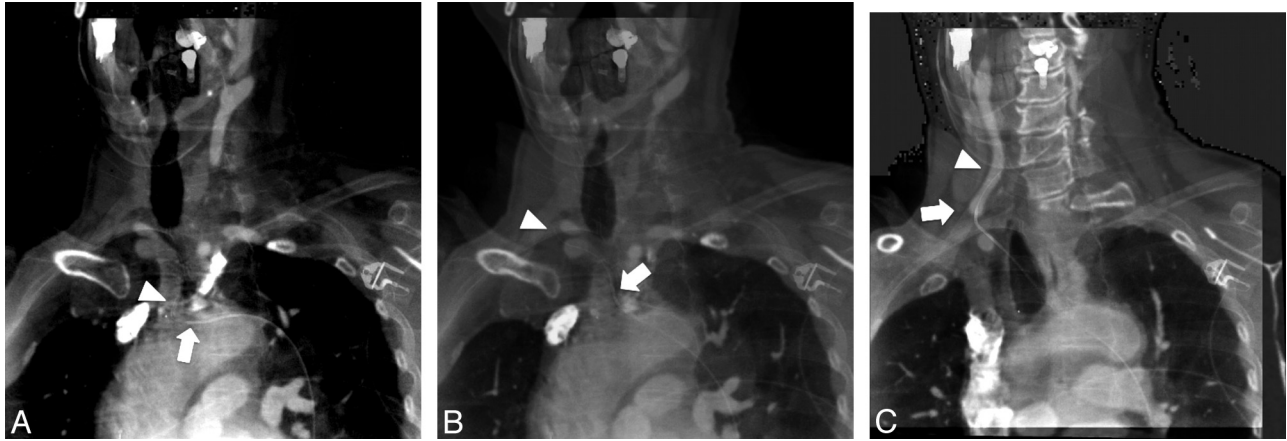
A 68-year-old woman was referred for diagnostic angiography of an aneurysm in the cavernous portion of the internal carotid artery. *A*, AP view of real-time fluoroscopy with superimposition of an MIP of a previously acquired CTA. A 5F Bern catheter (Boston Scientific, Natick, Massachusetts) with a Terumo wire (Terumo Medical, Somerset, New Jersey) can be seen in the brachiocephalic trunk. *B*, The wire is shown in the proximal right common carotid artery. The superimposed MIP of the CTA does not correlate well with fluoroscopy due to the different depth of the aortic arch and the proximal common carotid artery in the AP projection. *C*, After manual adjustment of the depth of the MIP, the road-mapping of distal vasculature until bifurcation is available again for further navigation of the catheter. Arrows indicate the tip of the catheter, and the arrowheads indicate the tip of the wire.
